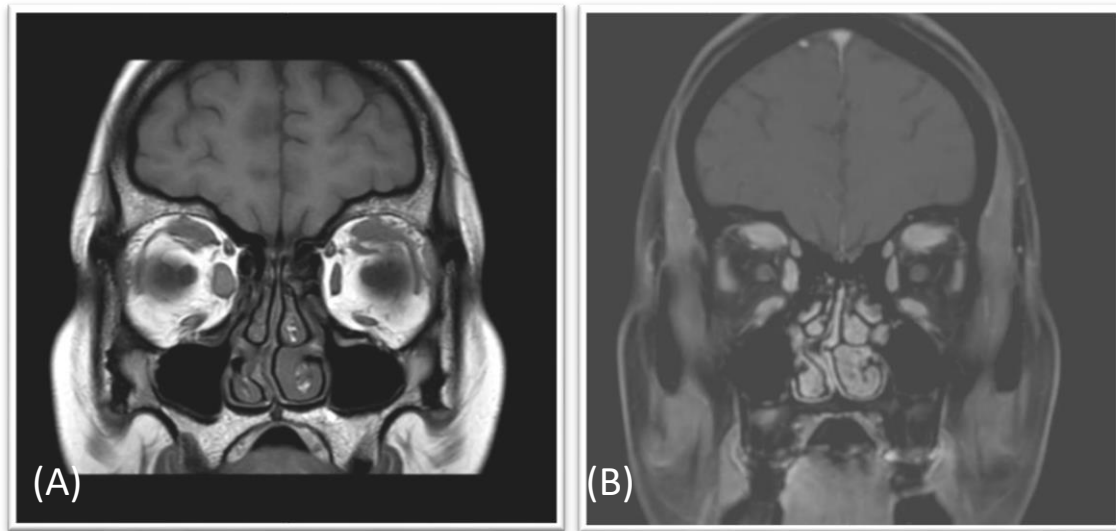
MRI Brain A (plain) & B (contrast), showing thickened and enhancing superior recti muscles
